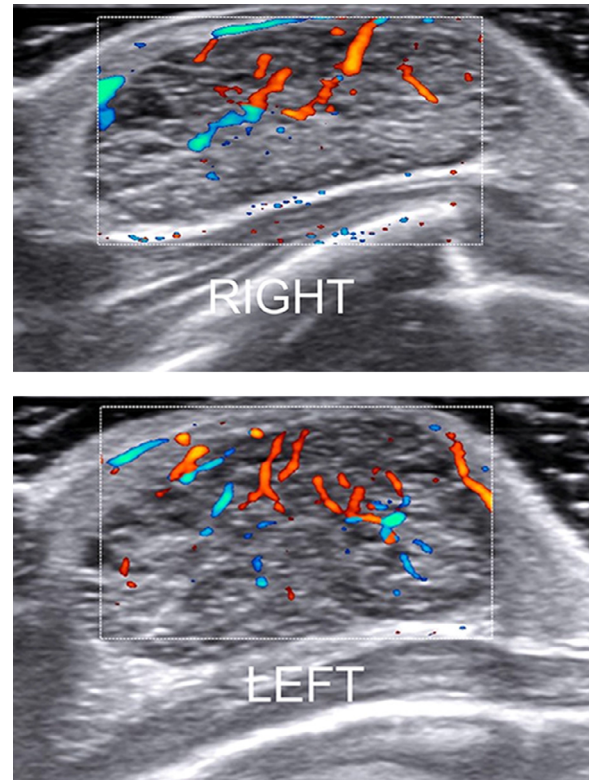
Color Doppler ultrasound of the right and left breast mass showed internal vascularity
